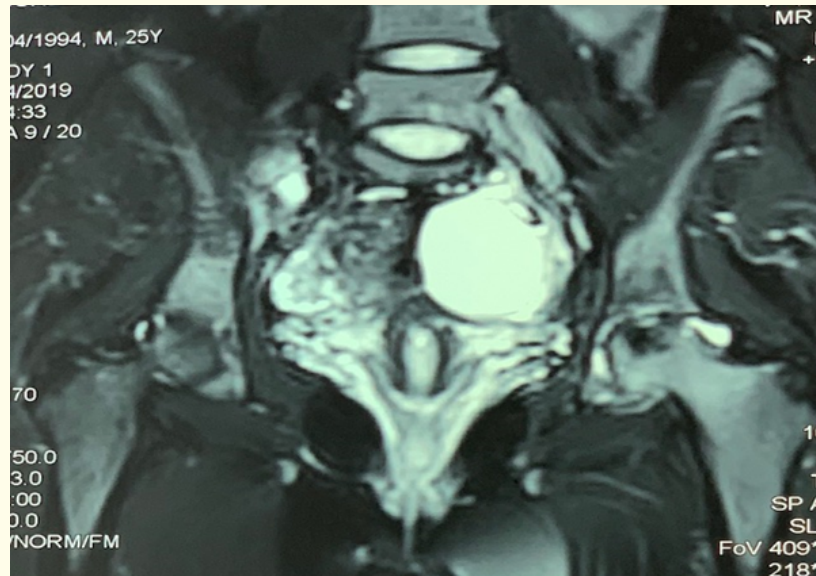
Pelvis MRI showed left adnexal mass.
